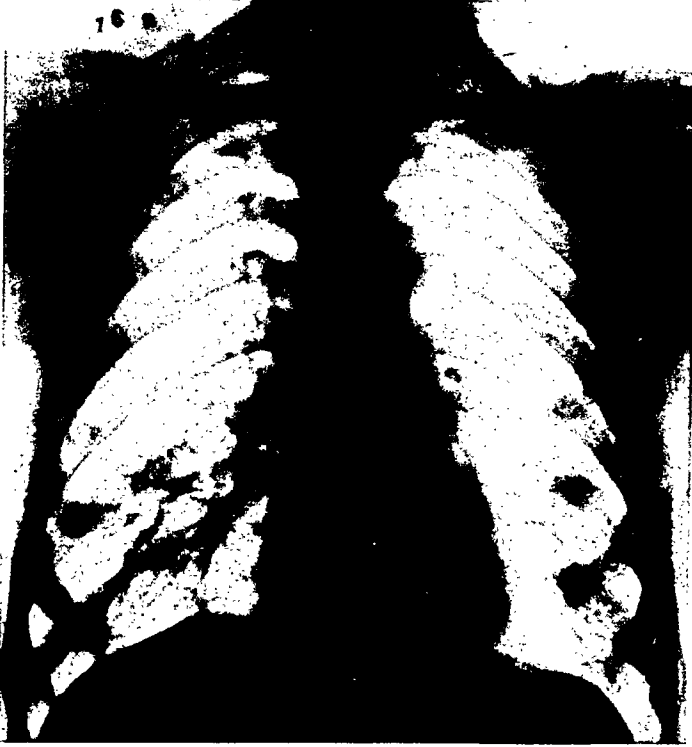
Bronchiectasis right lower lobe. Spontaneous cure. X-ray three years later.
